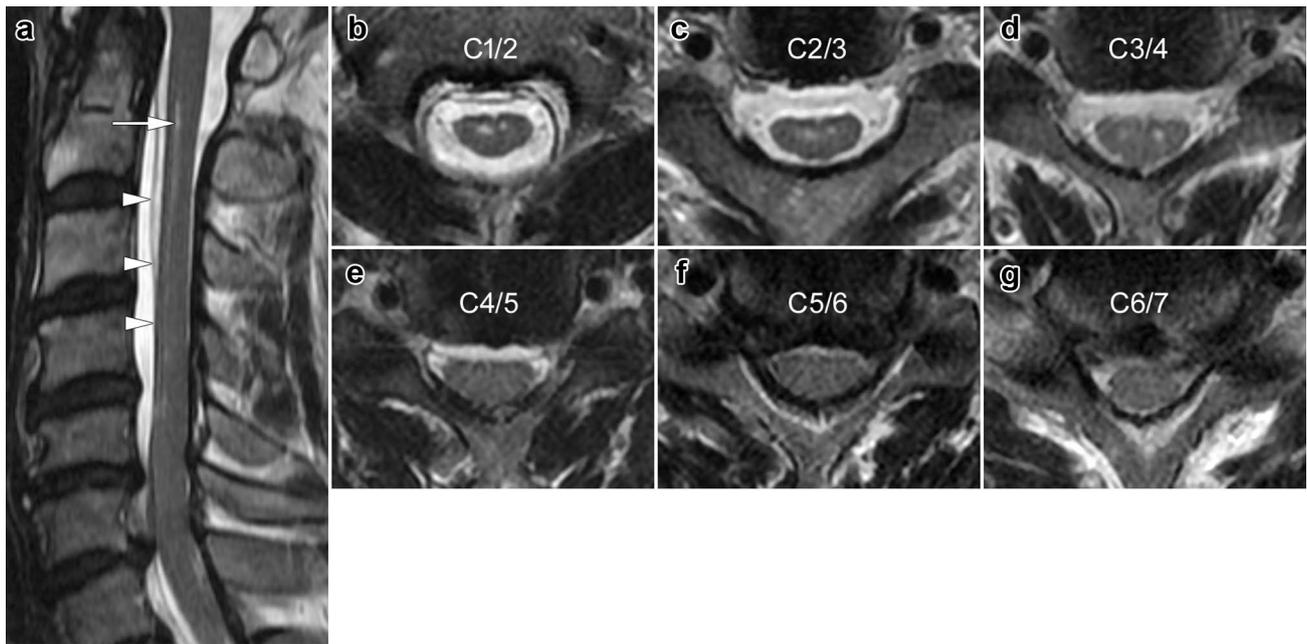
(Case 5) Sagittal (a) and axial (b–g) T2-weighted MRI of the cervical spine showing bilateral high-signal-intensity lesions located at the anterior horns at the C2–C4 levels (arrow) and ventral epidural
